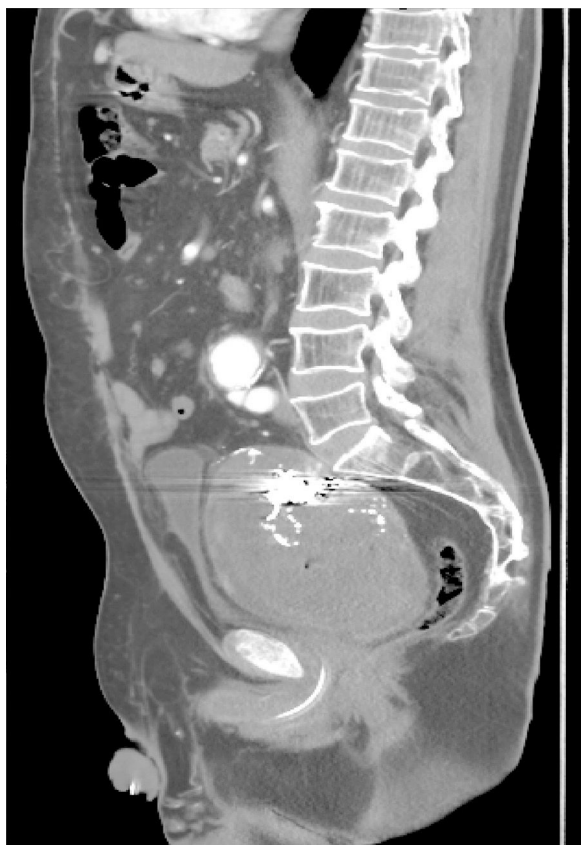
CT: aneurysm of the hypogastric artery compressing the rectum (sagittal view).
